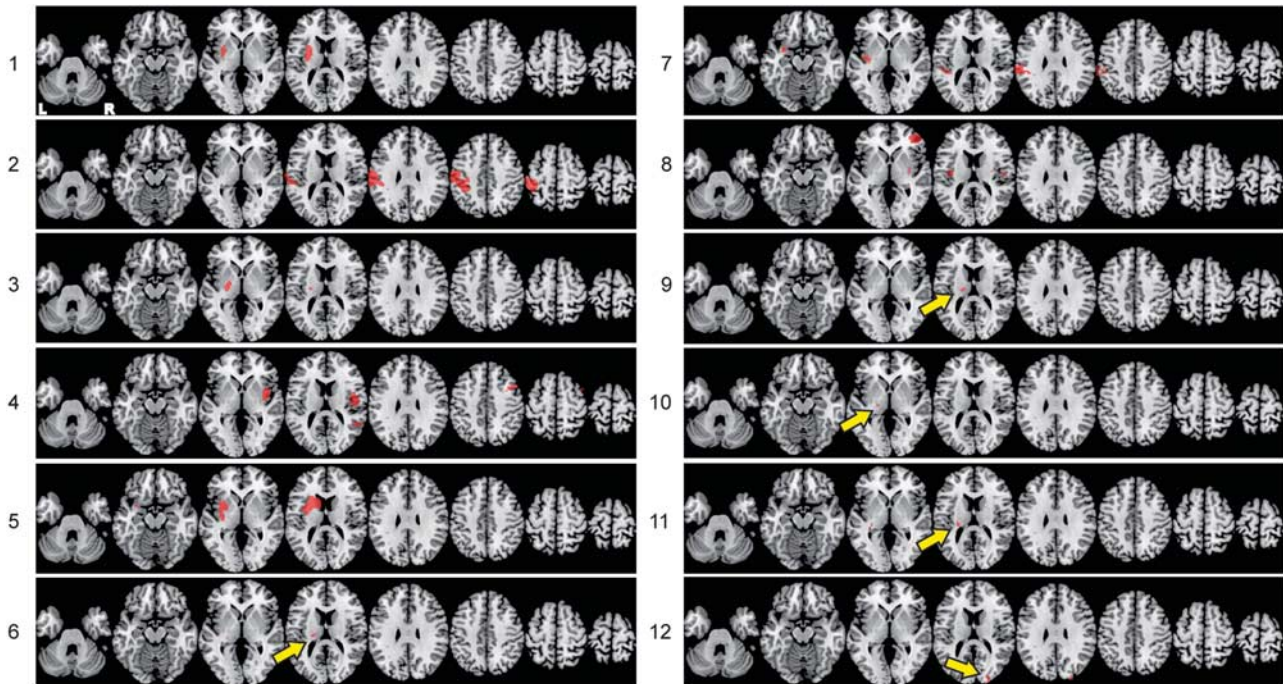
Individualized lesion masks. Axial slices of the individual lesions based on DWI/FLAIR images registered to standard MNI152 space. z-coordinates are identical to those presented in Figure 2. Red color depicts areas of hyper-intensity, i.e., the lesioned areas. Yellow arrows are pointing to small lesion areas to improve visibility.
